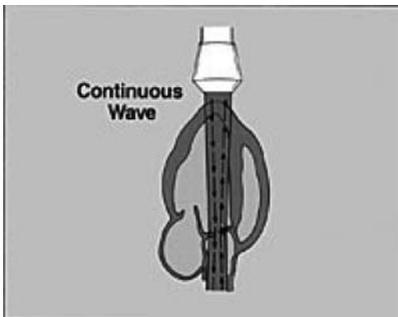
Continuous generation and reception of CW Doppler in the heart.
